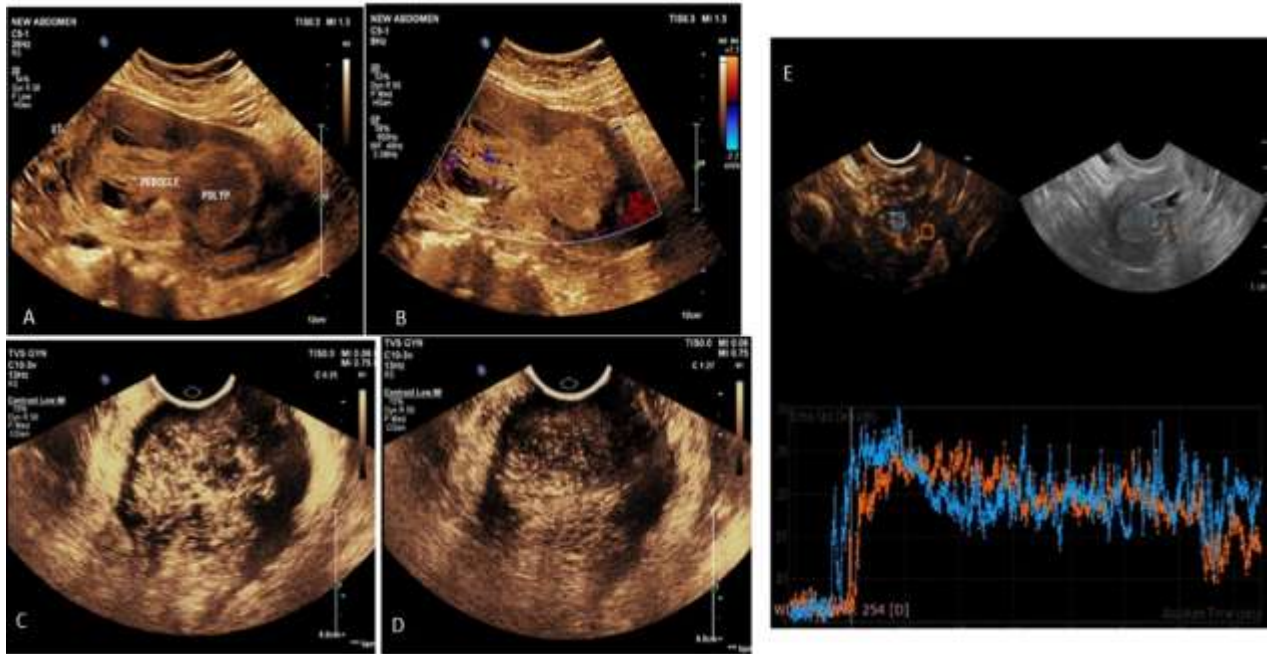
B mode (A) and color doppler (B) images of the fundal polyp showing early arterial enhancement (C) and quick washout (D). TIC curves (E) blue ROI in the polyp and red ROI in the normal myometrium.
